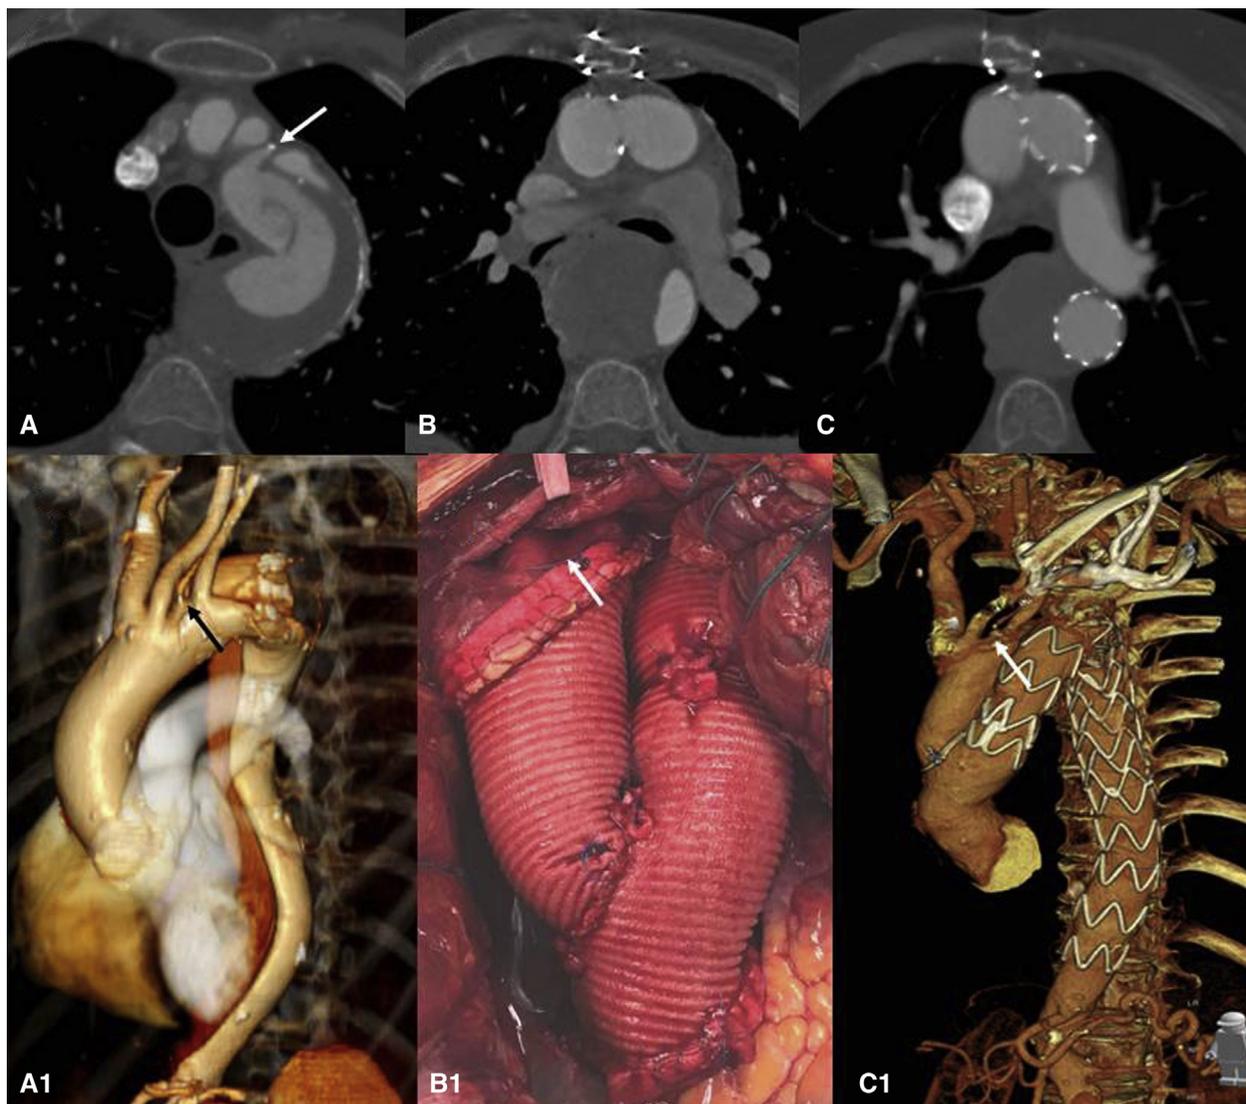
Hybrid type II arch repair: (A) CTA with volume rendering reconstruction (B) of a type B acute aortic dissection and aneurysm of the descending thoracic aorta with demonstration of the ILVA; A, white arrow; A1, black arrow) from the distal arch between the LCCA and the LSA. Hybrid type II arch repair: The origin of the ILVA (B1, white arrow) was transposed along with the innominate, LCCA, and LSA using a SAT debranching graft according to the Griep “arch first” technique. Follow-up CTA showed the complete exclusion of the dissection and descending aneurysm (C) as well as the patency of the ILVA (C1, white arrow), and the good alignment of the SG at the origin of the debranching graft (C1).
